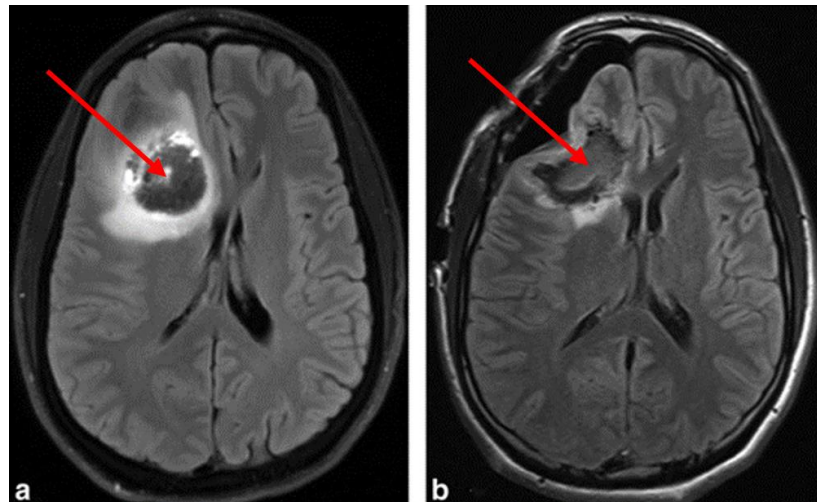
a) Preoperative MRI, b) Intraoperative MRI taken during tumour resection [67]. Red arrow indicates tumour site.
